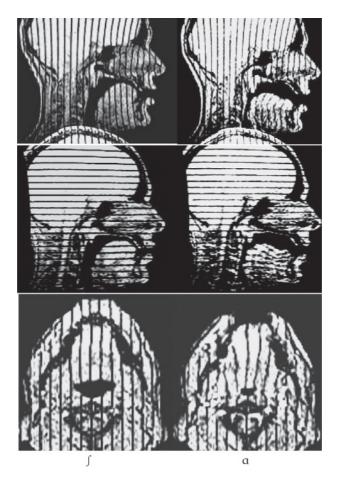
Tagged MR images in three planes. The left column shows the reference state of the tongue, just after the tags were applied during the sound $/\int$ / The right column shows the tongue in the deformed state, after the tongue has moved into $/\alpha$ / position.
